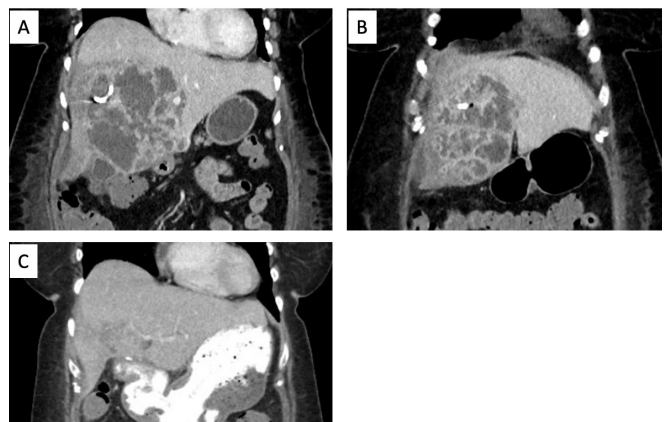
Computed tomography images of a 65-year-old female who developed intermittent fevers to 103°F (39.4°C) approximately 2 weeks after dental work. She presented in septic shock and a percutaneous drain was placed by interventional radiology. Two weeks later she continued to have a fever, at which point images A and B were obtained. Abscess fluid microbiology and blood cultures revealed *Streptococcus milleri*. The patient underwent surgical debridement. Image C was obtained 3 weeks postoperatively.
